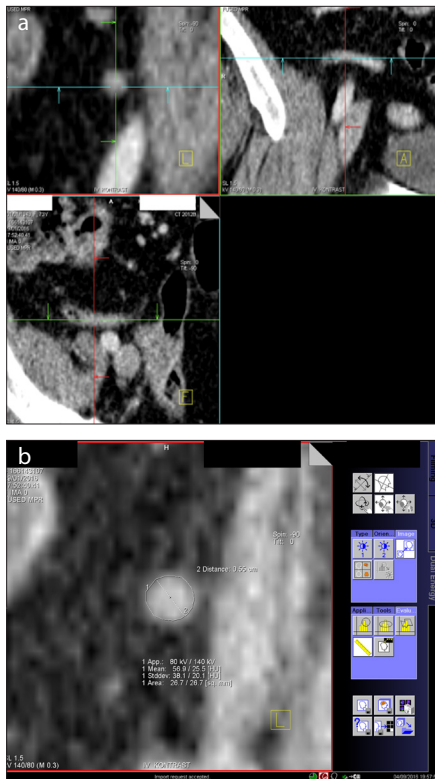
a, b. An example of appendiceal density measurement. Panel (a) shows the acquisition of true axial image (left upper image) through coronal and sagittal computed tomography (CT) images. Panel (b) shows the measurement of appendiceal density in the reformatted true axial image of appendix vermiformis.
